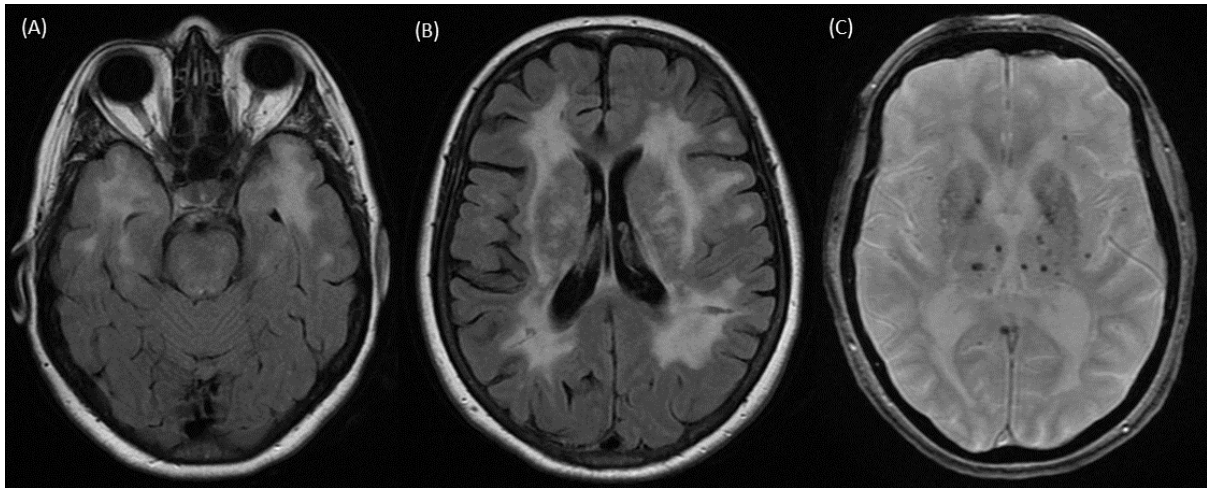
Radiological features of CADASIL on MRI. White matter hyperintensities (WMH) involving the anterior temporal pole (A) and external capsules (B) are seen on T2/FLAIR MRI sequences. (C) Subcortical cerebral microbleeds can be seen in some patients on T2* Gradient Recalled Echo (T2* GRE) sequences.
